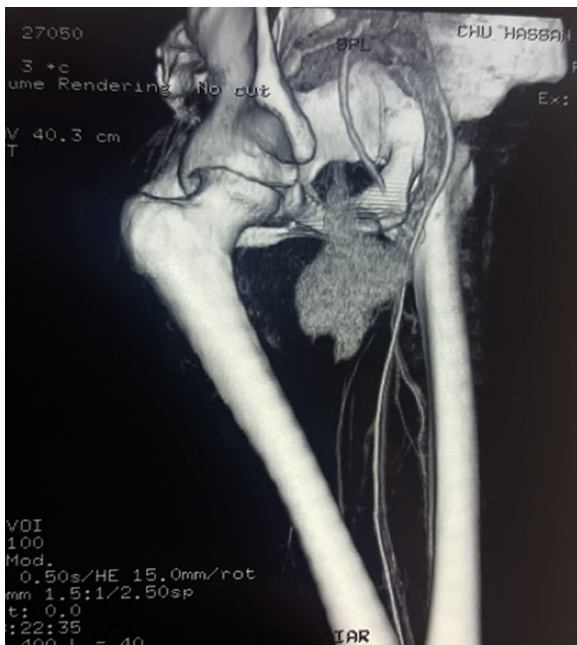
CT scan with tridimensional reconstruction showing an aneurysmatic sacular formation in the dependence of the right common femoral artery.
